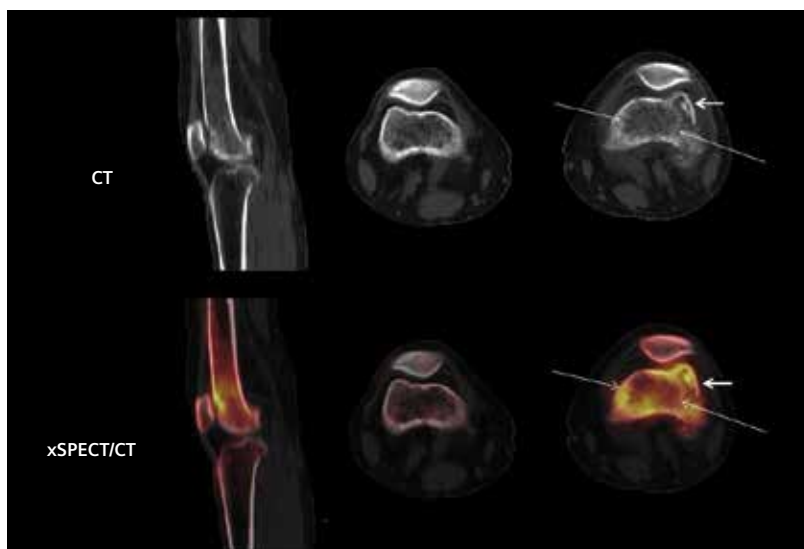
CT and SPECT/CT show an ill-circumscribed mass in the lower end of the left femoral shaft, with minor sclerosis and cortical erosion around it (*thin arrows*), and increased osteoblastic activity shown around the mass corresponding to the zone of cortical erosion (*thin arrows*). There is also an undisplaced fracture in the anterolateral edge of the lateral condyle (*thick arrow*), with well-defined fracture lines seen on CT and a small fracture fragment just below the fractured cortical rim. Fusion of xSPECT and CT shows sharp delineation of the increased uptake in the cortical bone involving the undisplaced fracture, which involves the lateral patellar facet, but does not extend into the knee or lateral patella-femoral joint space. The smaller fracture fragment just below the cortical rim also shows high uptake on xSPECT Bone, reflecting the increased bone turnover in that segment.
